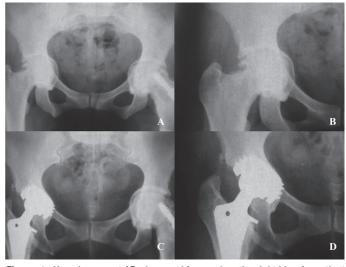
X-ray images at AP plane and focused on the right hip of a patient with bilateral Otto pelvis treated with total hip arthroplasty (THA), non-cemented, with threaded cup CO-10, right. A – Preoperative hip X-ray image. B – Focused preoperative X-ray image. C – Postoperative hip X-ray image. D – Focused postoperative X-ray image evidencing clear acetabular remodeling.
